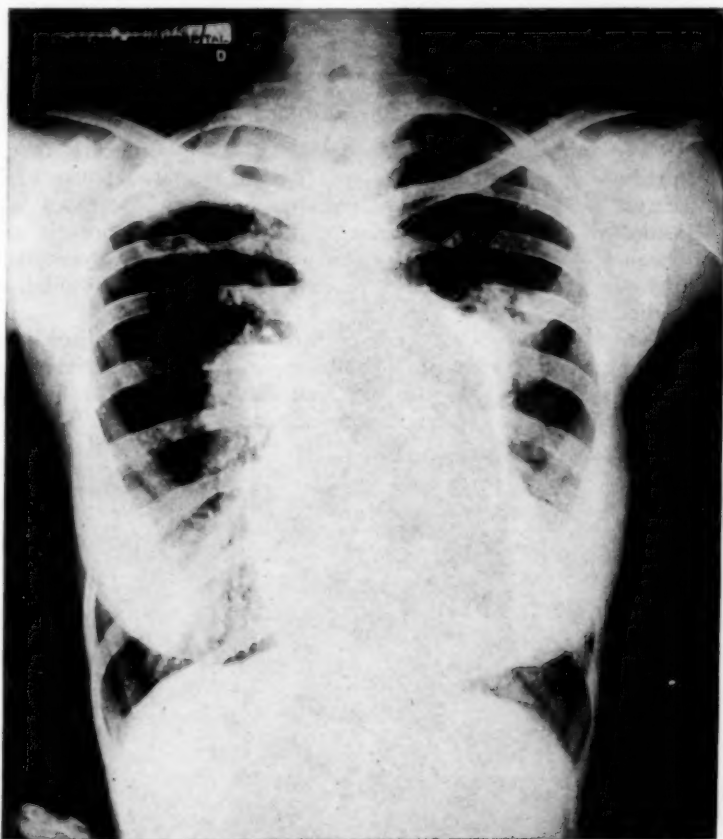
Roentgenogram of chest showing the large globular heart, the small aorta, the pronounced accentuation of the pulmonary conus, the densities of the enlarged pulmonary arteries, the pulmonary changes due to the lesions of tuberculosis.
